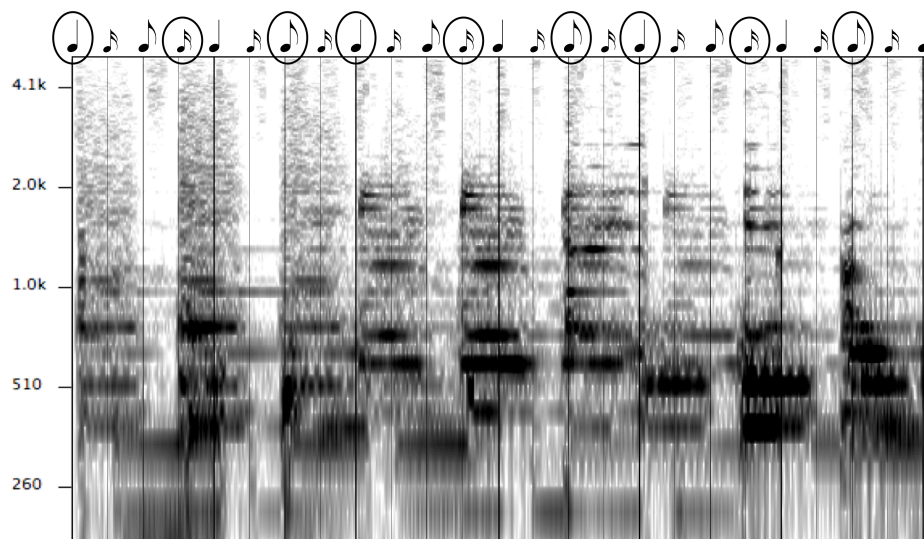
Excerpt from sonogram of Rinôçérôse’s *It’s Time To Go Now!*, 0:00–0:03, placed in a grid with note values. Entry points are highlighted with circled notes.
